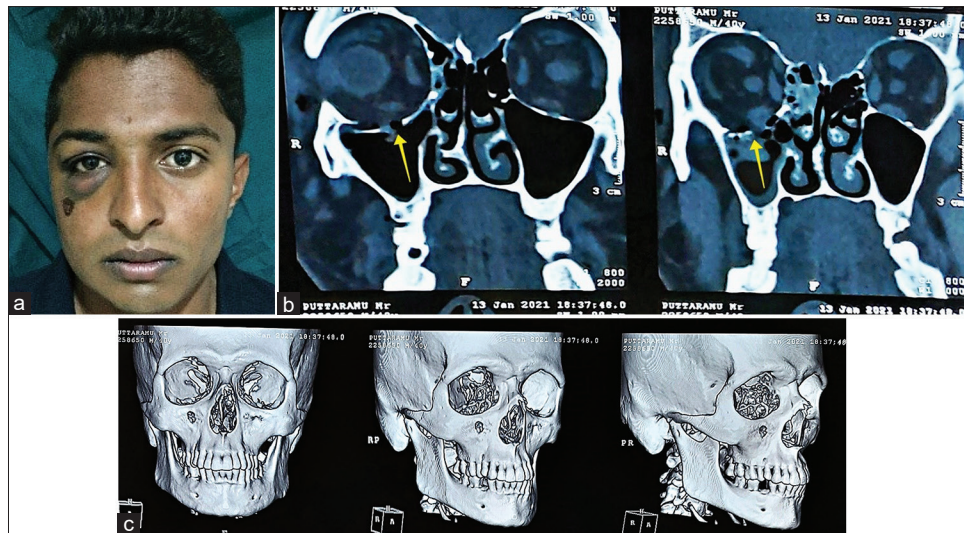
(a) Preoperative clinical image of the patient. (b) Preoperative CT showed herniation of periorbital soft tissue into the maxillary antrum. (c) Preoperative 3D CT showed intact orbital rim. CT: Computed tomography
